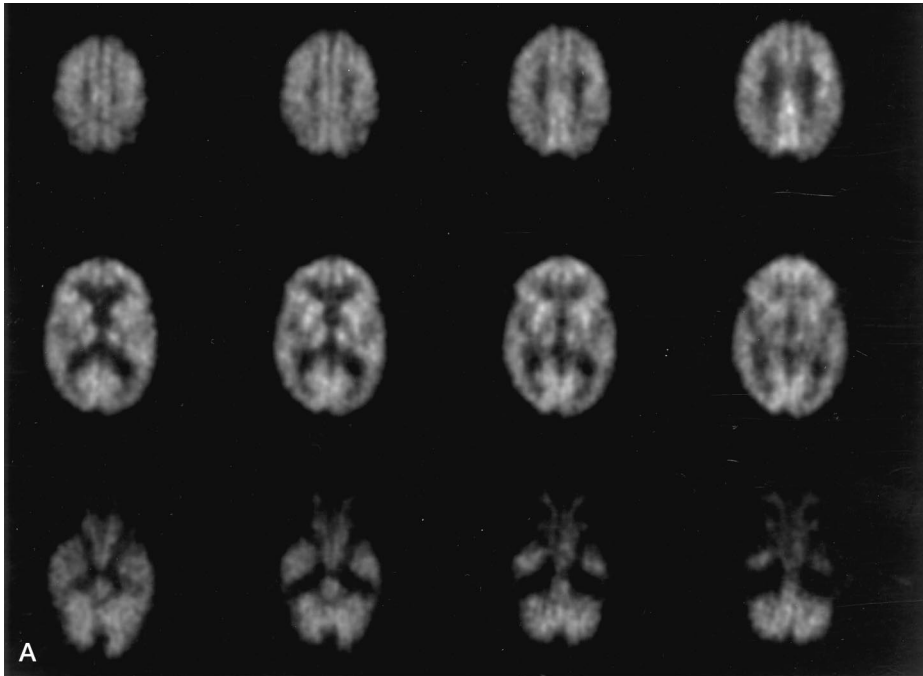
(a) An FDG-PET scan from a patient with mild AD shows mildly decreased activity in both temporoparietal regions. (b) The corresponding MISRS scoring sheet is included for this patient.
